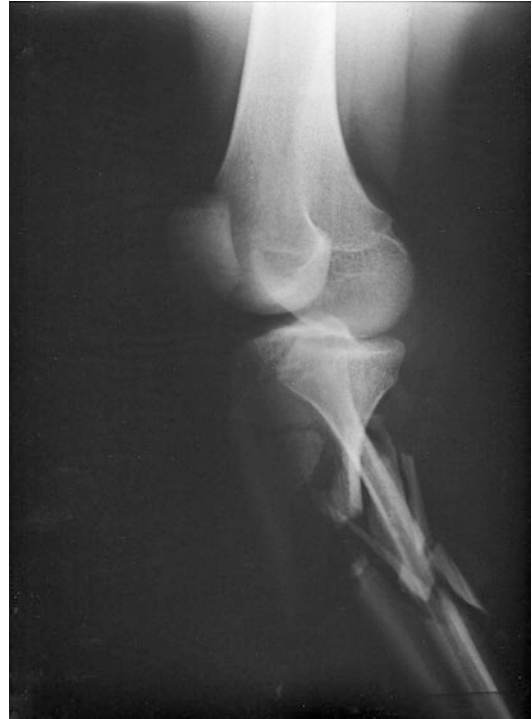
Lower-leg X-Ray demonstrates high-energy injury
